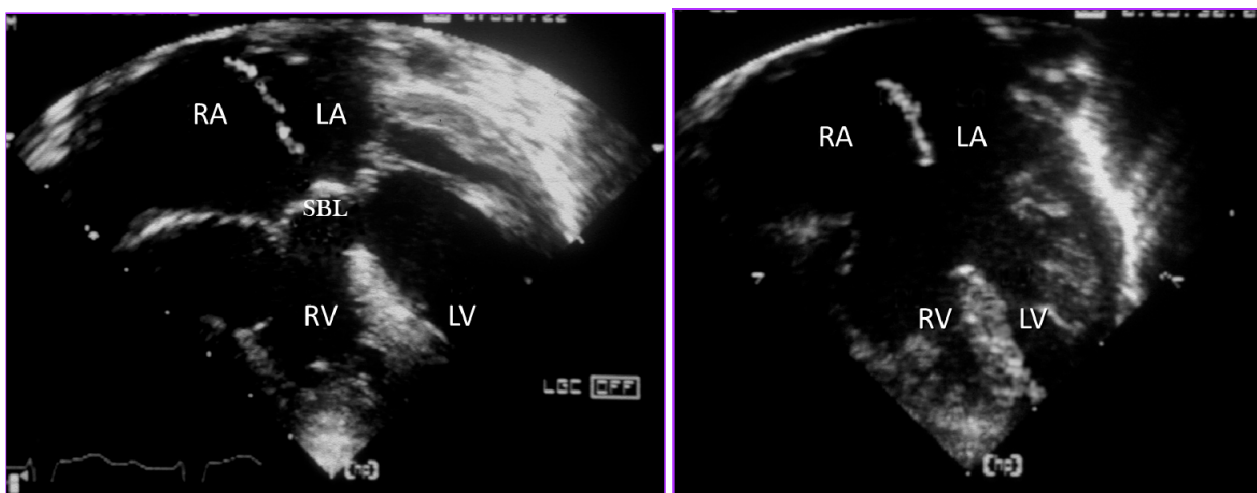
Echocardiographic sections from a heart with complete AVSD (a) during ventricular systole with the valve closed and (b) during diastole with the valve open.
